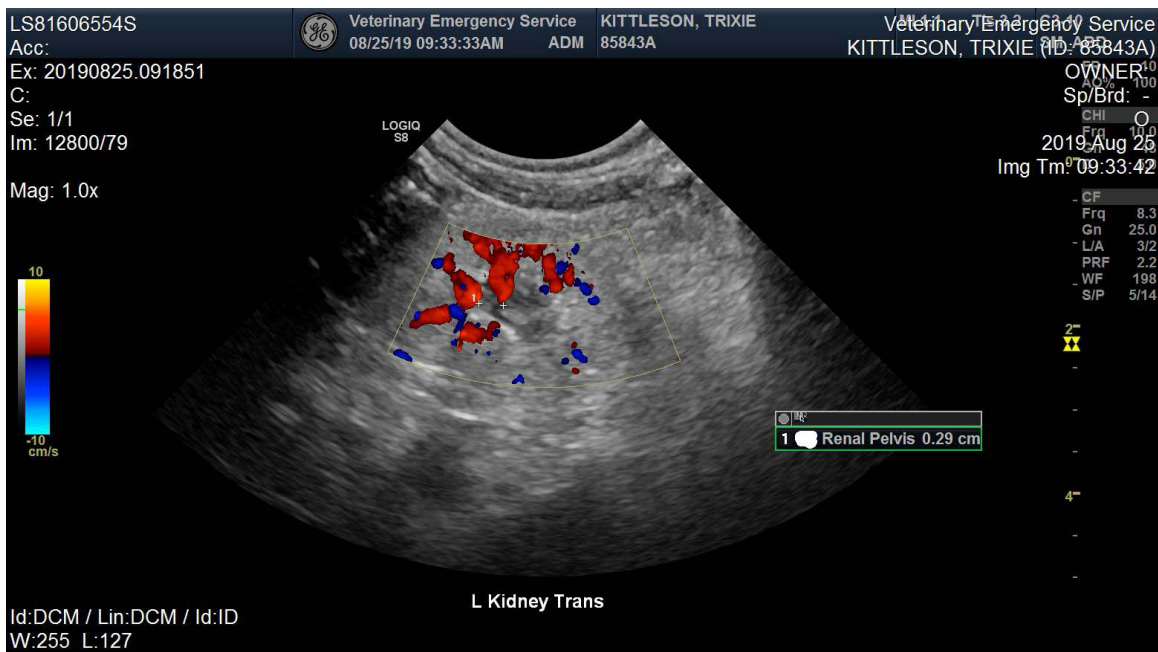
Transverse view of the left kidney. Color Doppler was used to differentiate the vasculature while identifying a dilated and hyperechoic renal pelvis (2.9 mm).
